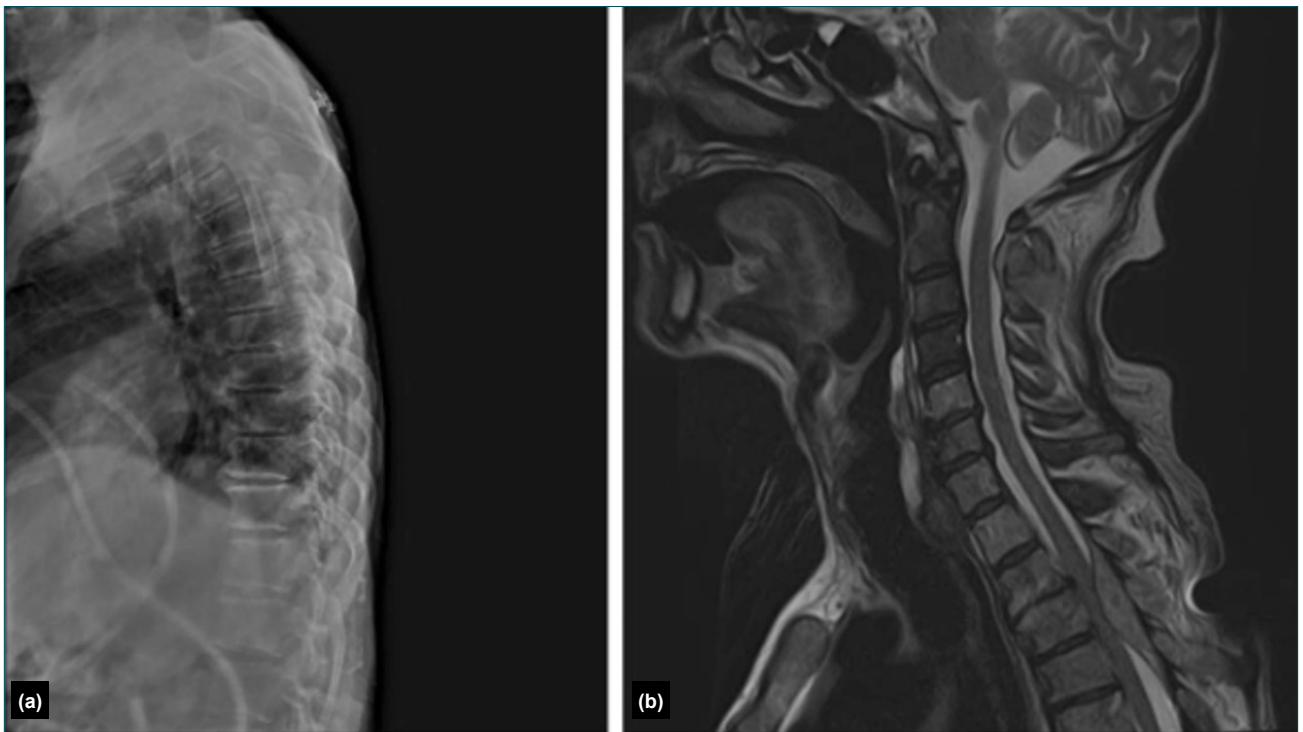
(a) Plain radiography and spinal computed tomography (CT) of the region corresponding to spinal tenderness revealed no identifiable pathology. (b) Spinal magnetic resonance imaging (MRI) demonstrated an extradural lesion at the T3 level, suspicious for a metastatic mass. Following consultation with the relevant specialties, the patient underwent surgery 10 hours after presentation to the emergency department.
